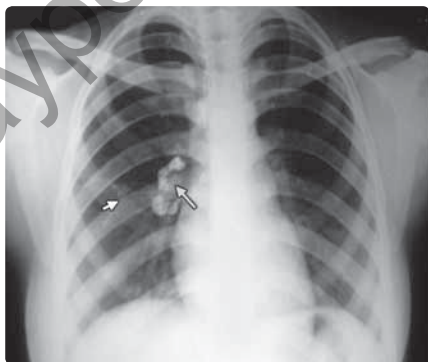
Chest X-ray PA view showing primary complex with large hilar (long arrow) and small parenchymal calcification (small arrow)
